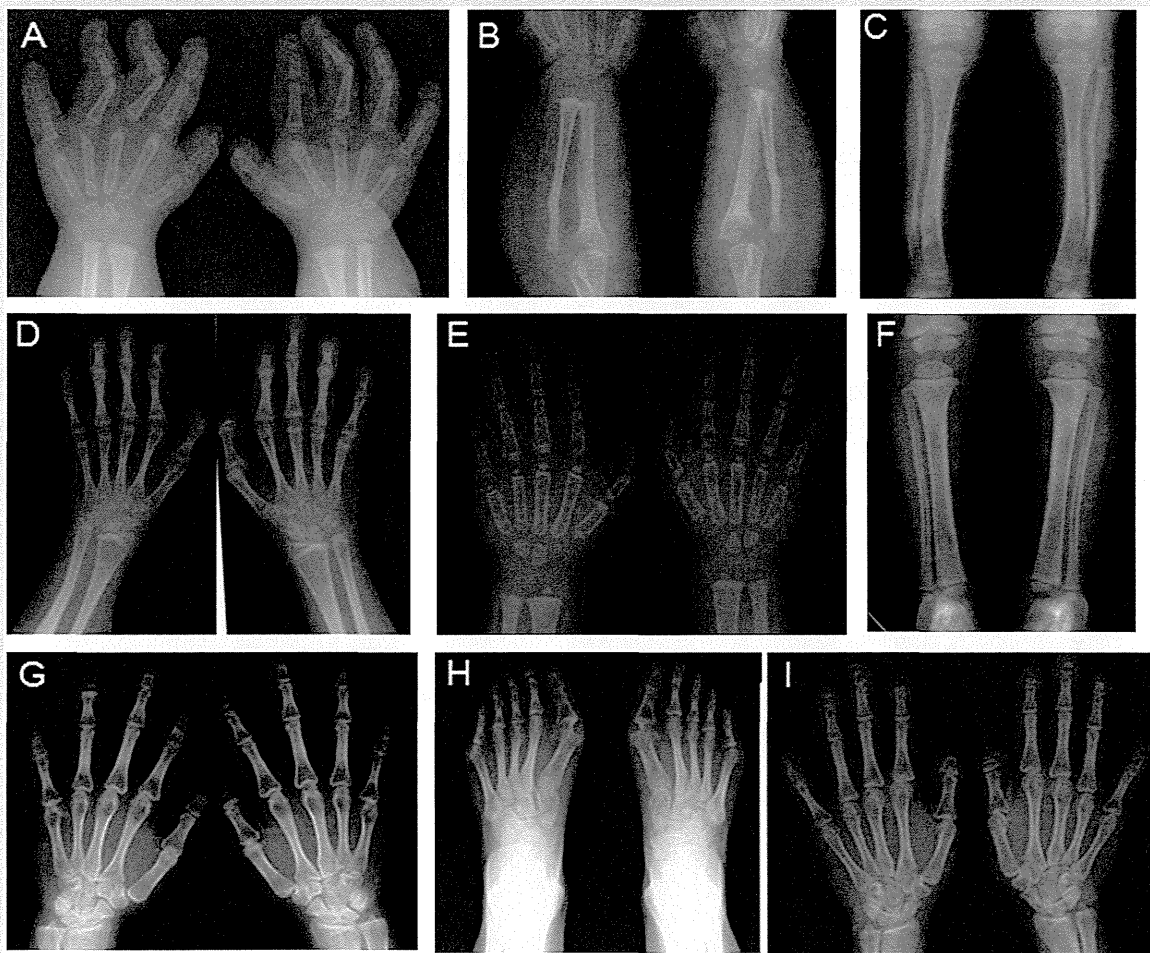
Radiographs of the hands and feet. Patient 1 showed acroosteolysis of both the second and fifth fingers along with slender short tubular bones (A), twisted radii with proximal radioulnar dislocation (B), bowed tibiae and serpentine fibulae (C). Patient 2 at 14 years of age; acroosteolysis of the distal phalanges evident (D). Patient 3 at 2 years of age showing no acroosteolysis (E), and mild bowing tibiae (F). Bilaterally symmetrical acroosteolysis in distal phalanges was shown in Patient 4 (G/H) and Patient 6 (I).
